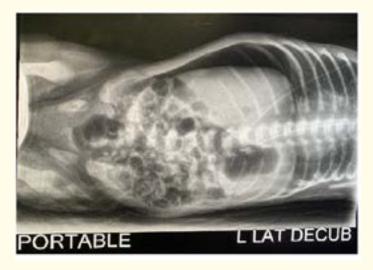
X-ray showing clear extensive pneumoperitoneum in lateral decubitus.
